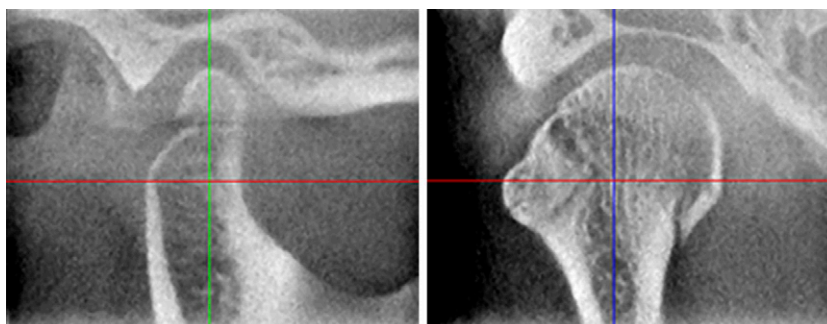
CBCT of intra-articular fractures. Reproduced from Larheim and Westesson⁹¹ with permission from Springer.
